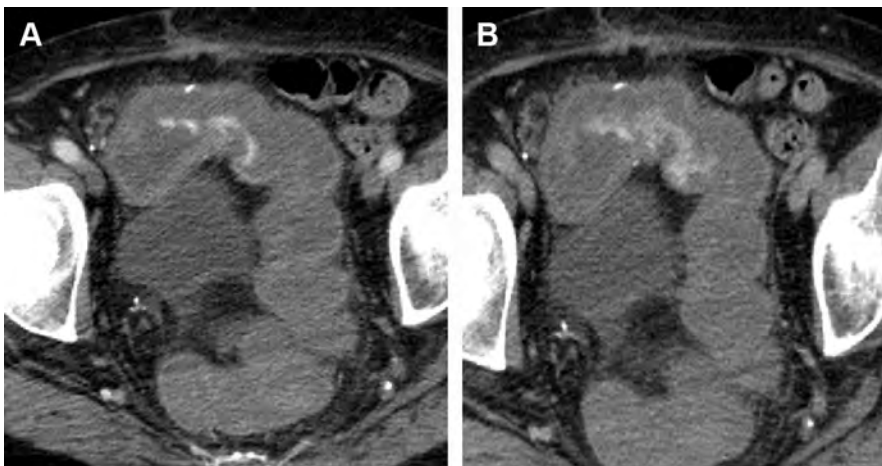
CTA of active GI bleed. An 87-year-old woman with history of hemicolectomy due to colon cancer presents with hematochezia. Axial arterial phase (A) and portal venous phase (B) images demonstrate contrast extravasation into the sigmoid colon adjacent to the anastomosis. Note that there is increasing extravasation on delayed images. A subsequent sigmoidoscopy revealed ischemic colitis at the surgical anastomosis.
